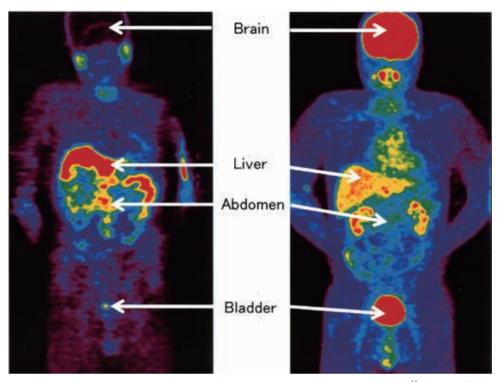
Typical whole-body PET images (Maximum Intensity Projection) using ¹⁸F-choline (left) and ¹⁸F-FDG (right). Physiological accumulation of ¹⁸F-choline is observed in the liver and abdomen. High-level accumulation of ¹⁸F-FDG is observed in the brain and bladder.
